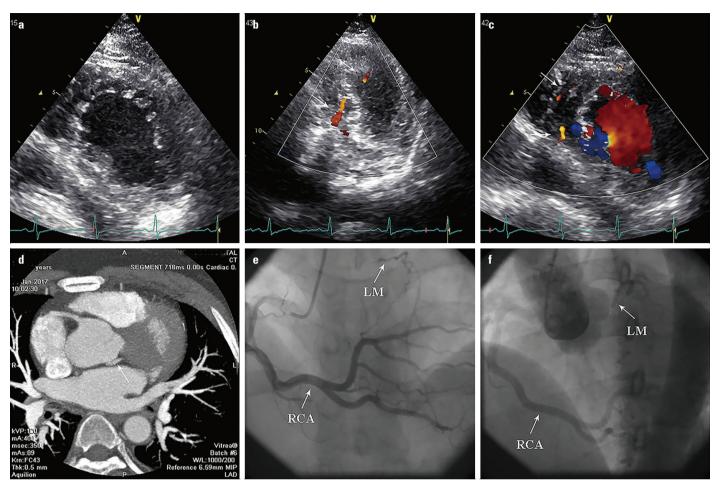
Echocardiography shows (a) left ventricular noncompaction with echogenic endocardium and (b, c) coronary collaterals (arrow). (d) Computed tomography angiography shows the LM (arrow) is unconnected with the aorta. (e, f) Coronary angiography shows a moderately dilated RCA arising from the right aortic sinus and a hypoplastic left coronary artery filled retrograde via collaterals, ending blindly at the LM and unconnected with the left aortic sinus
